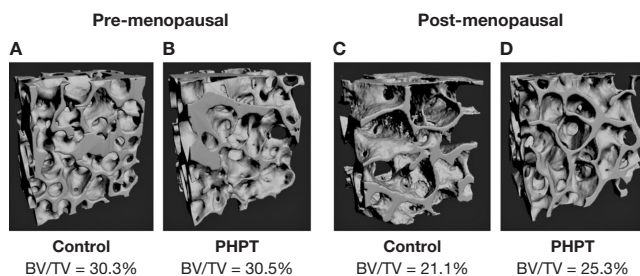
Microarchitectural features in pre- and post-menopausal women with primary hyperparathyroidism (PHPT). 3D microcomputed tomography reconstructions of cancellous bone in pre- and post-menopausal women with PHPT (B and D), and normal controls (A and C). [Adapted from (8)].
